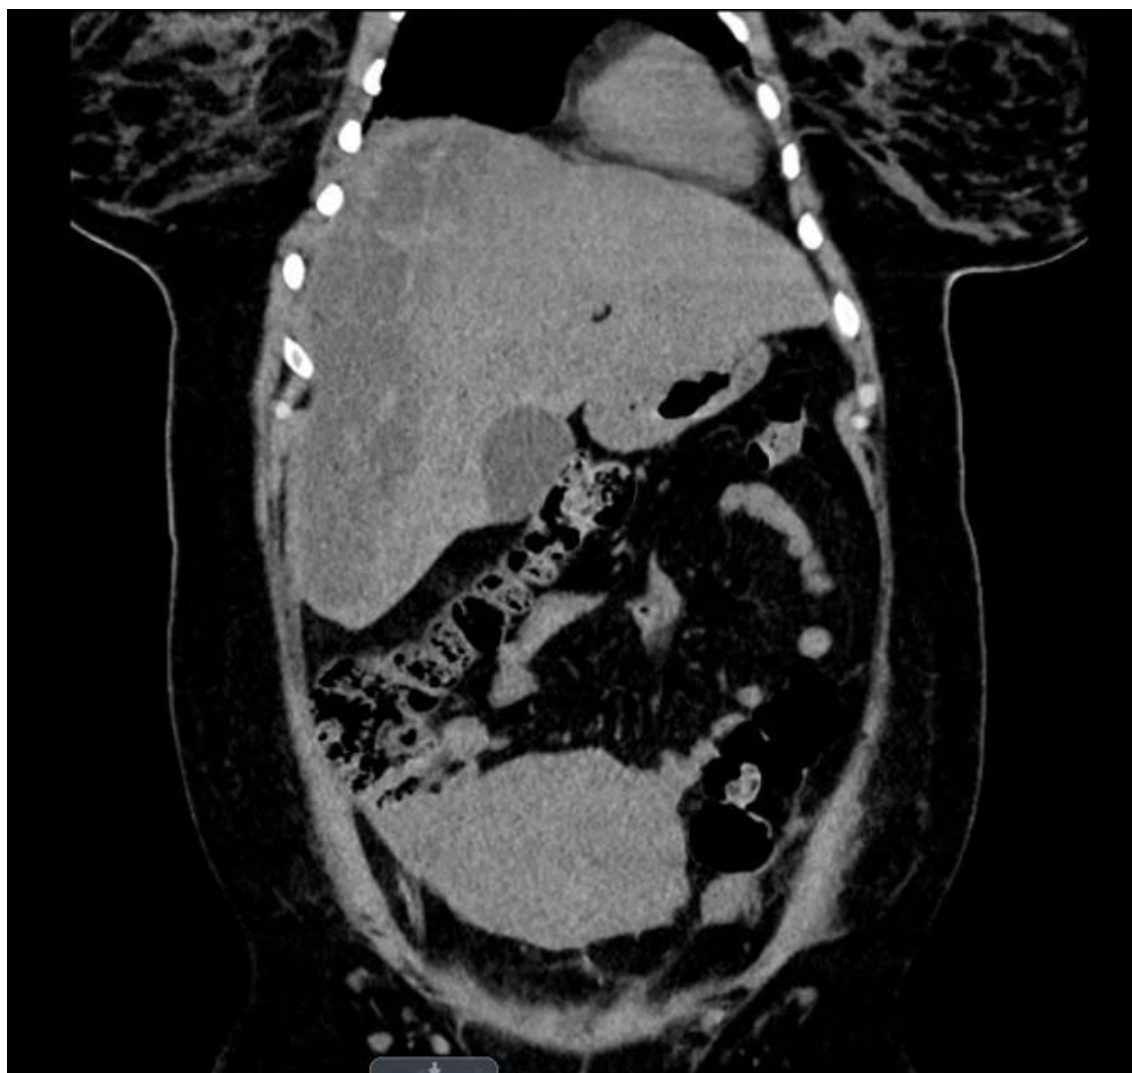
Coronal section of CTA abdomen and pelvis demonstrates subcapsular hematoma.
